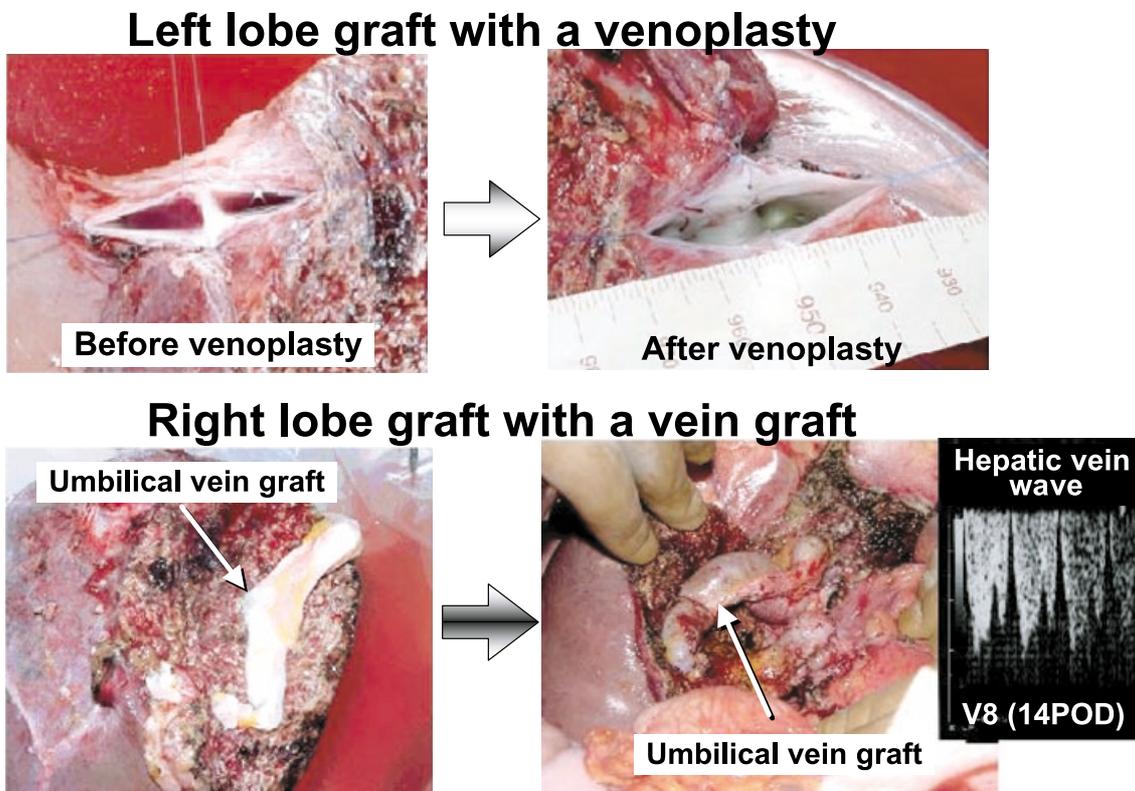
Venoplasty and reconstruction of venous tributaries of middle hepatic veins. (Upper column) The multiple hepatic veins in a left lobe graft is made to one lumen (venoplasty). (Lower column) The venous tributaries (V5 and V8) were reconstructed using a recipient's umbilical vein. As a result, the venous wave in the ultrasonography maintained well for a long-term period.
